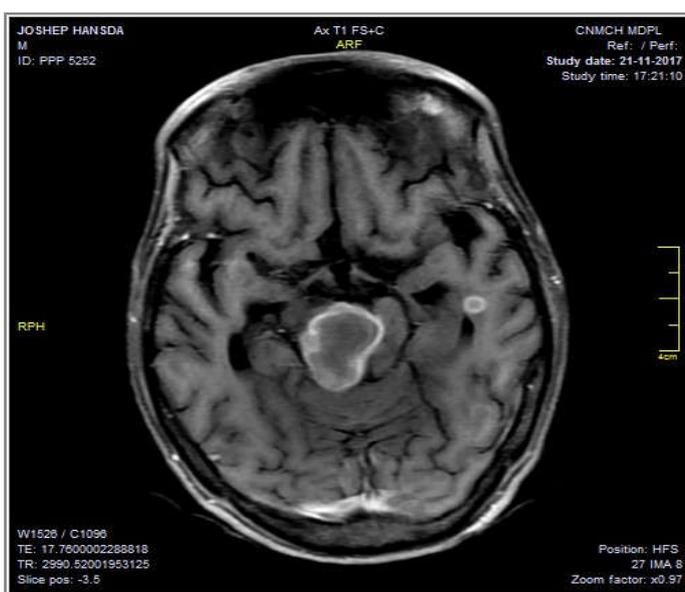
MRI Brain: features suggestive of tuberculoma/metastasis? In both cerebral hemispheres and a larger one in brainstem. Diffuse cerebral and cerebellar atrophy
